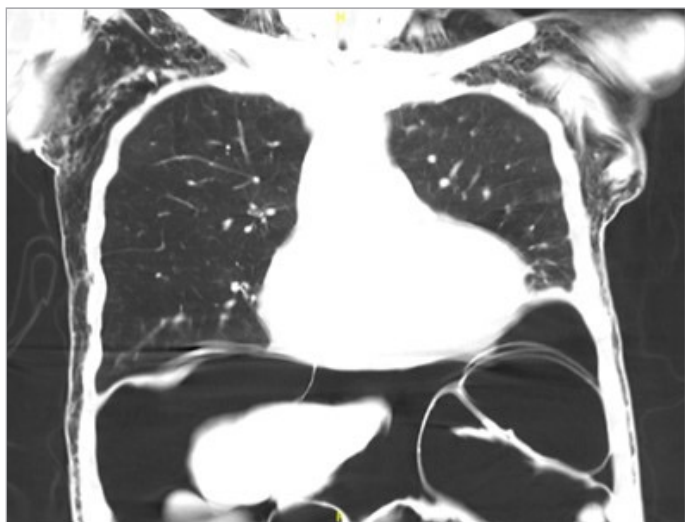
Subcutaneous Emphysema Visualized on CT Scan.
